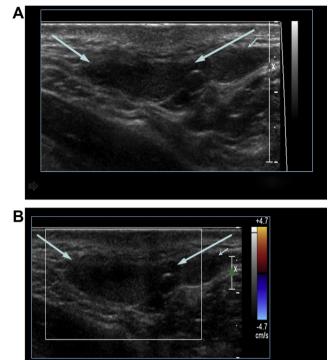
(A) Ultrasound reveals echogenic material in the initially anechoic fluid space adjacent to the small breast nodule (which was diagnosed as a fibroadenoma on ultrasound, small arrows), representing thrombosis (large arrows), and (B) color Doppler ultrasound shows no color flow signal in the cavity (arrows), indicating no active blood space.
